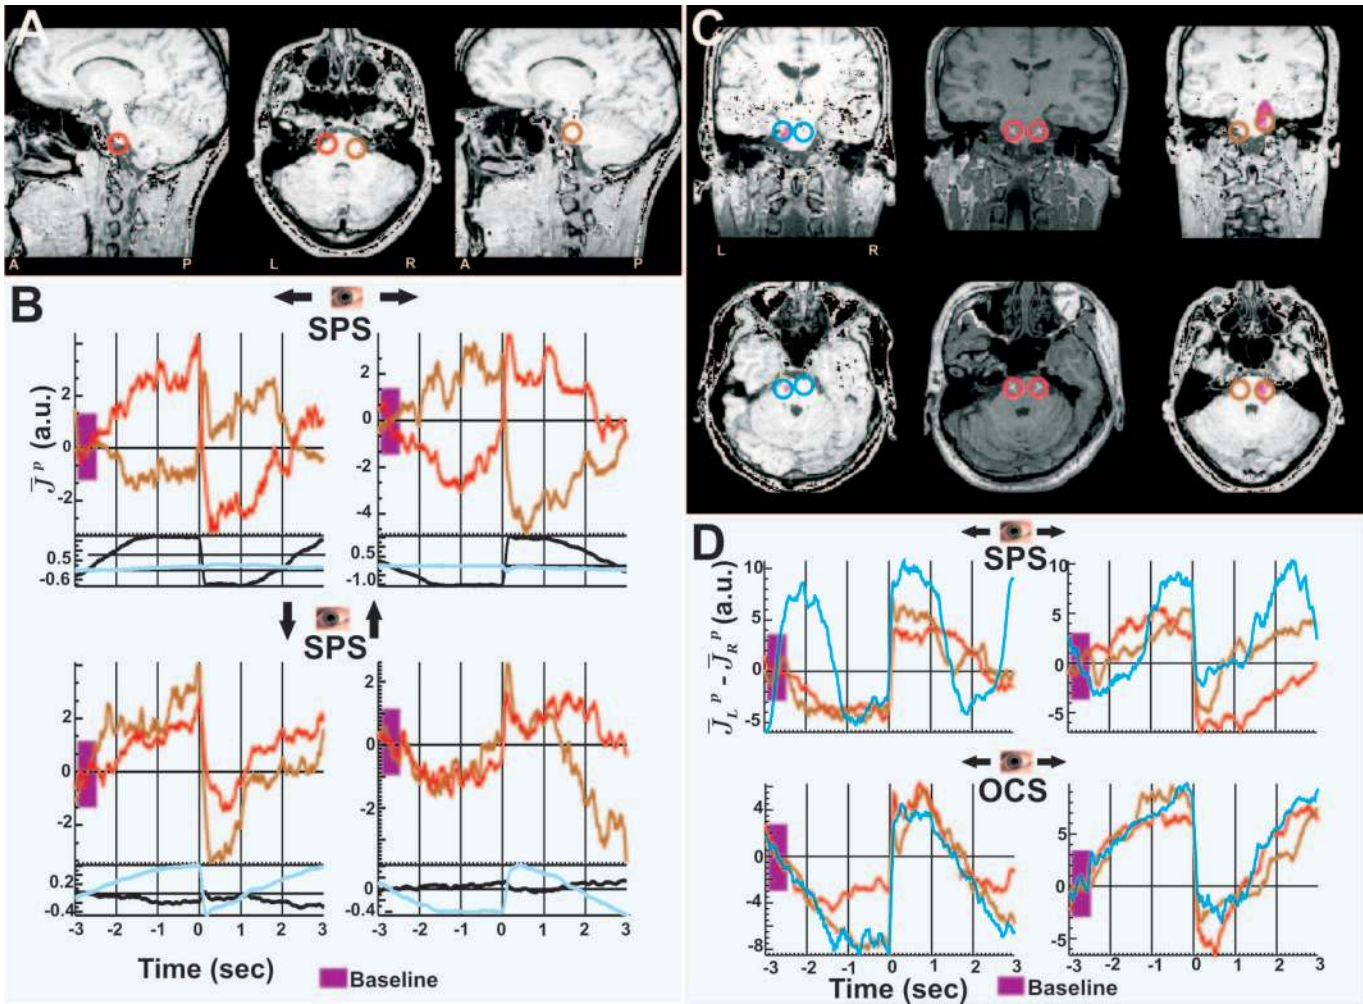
MFT estimates for the current density in the pons for OCS and SPS extracted from the 6 s long, low-pass filtered below 20 Hz MEG signal. (A) Red and brown circles mark the left and right ROIs for PNs for subject S2 (see coordinates in Table 2). Each ROI is superimposed on the left and right sagittal MRI slices and both are displayed together on a transaxial slice (middle). (B) MFT estimates for \bar{J}^p (defined as in Fig. 2), for the left (red, \bar{J}_L^p) and right (brown, \bar{J}_R^p) PN ROIs extracted from the average MEG signal and subsequently smoothed with running average filter of 0.1 s. The results are for subject S2 for SPS directed towards left, right, up and down, as verified by the corresponding EOG traces (horizontal—black, vertical—blue). (C) The pontine ROIs of three subjects in coronal (upper) and transaxial (lower) MRI slices. (D) Subtraction (enhances the difference) of MFT solutions in right PN from those in left PN ($\bar{J}_L^p - \bar{J}_R^p$), during SPS and OCS, eye movement in horizontal directions in the three subjects (traces of each subject bear the color of their pontine area in C).
